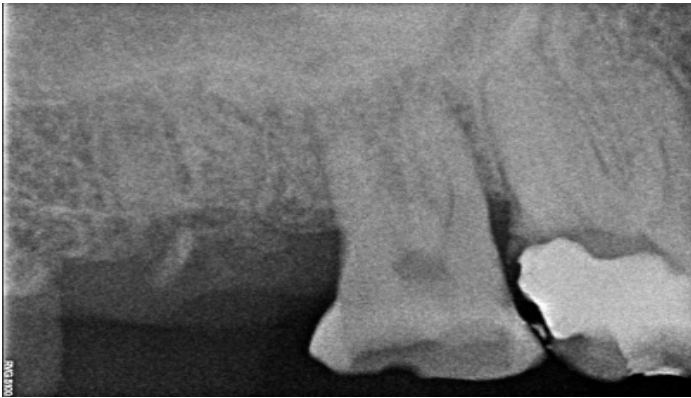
1 month post operative radiograph
